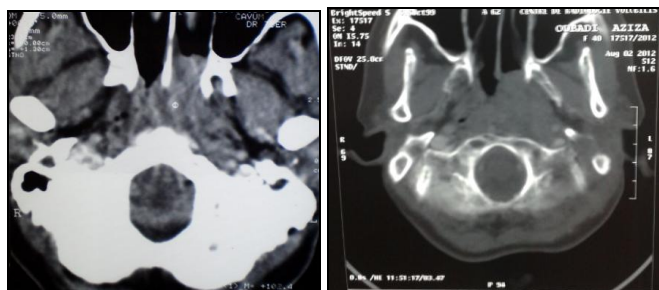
Fig b and c: CT images in axial section showing a tissue process of the nasopharyngeal.
